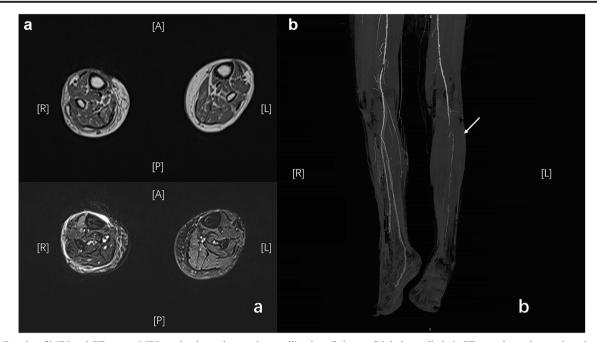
Results of MRI and CT scan. a MRI results showed extensive swelling in soft tissue of right lower limb. b CT scan showed stenosis and occlusion of right posterior tibial artery and peroneal artery (white arrow)
